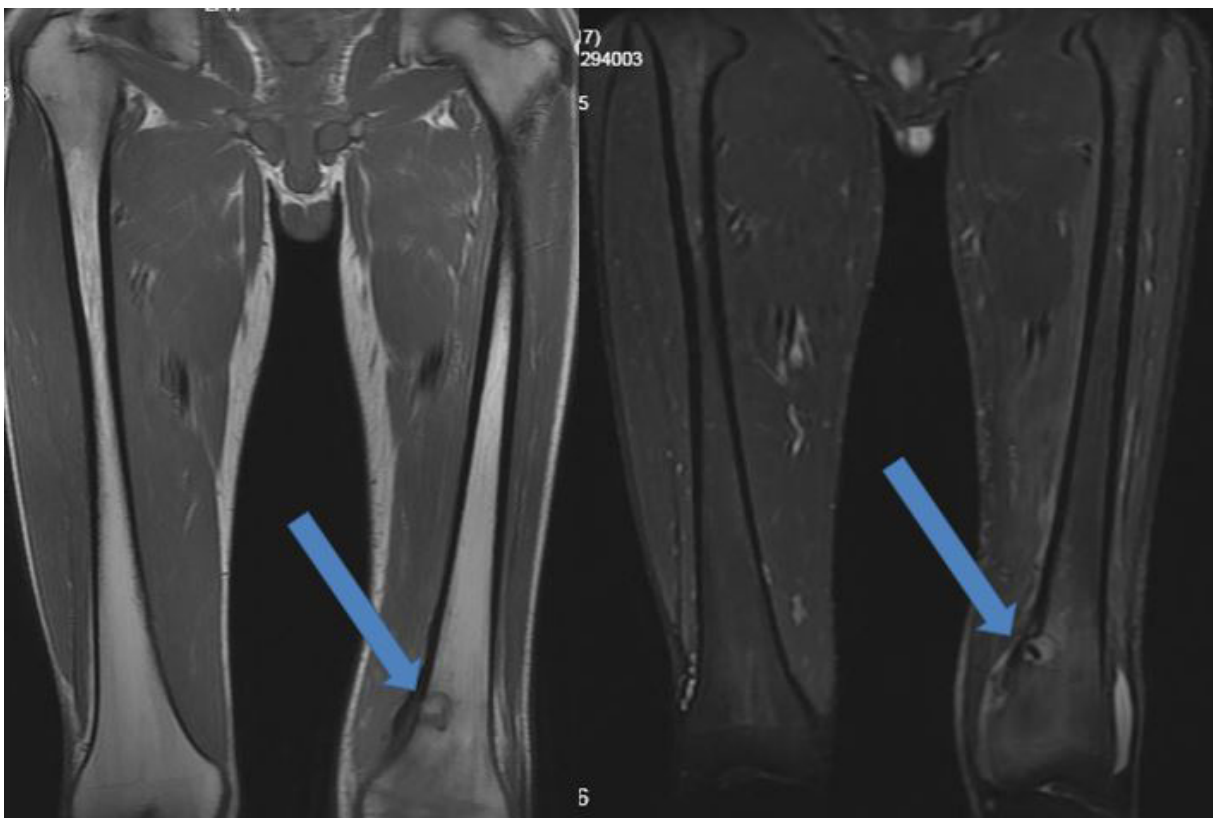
Osteoid osteoma distal to the left femur; typical appearance of the nidus and periosteal reaction on MRI
